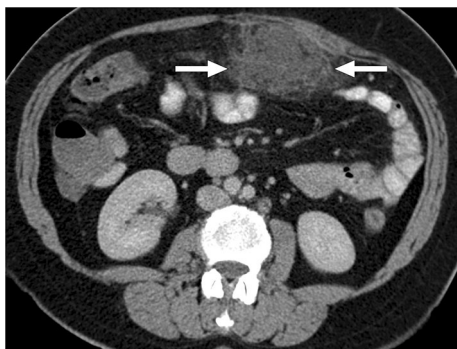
A 56-year-old female patient presented to the ER with recent-onset, well-localized, severe periumbilical pain. Axial plane postcontrast abdominal CT image showed an intraabdominal heterogeneous fat-containing mass-like structure within the greater omentum (arrows). The imaging findings were considered to represent an omental infarct. The patient responded well to the supportive medical treatment, and a follow-up CT 1 month after the initial presentation revealed complete regression (not shown)
